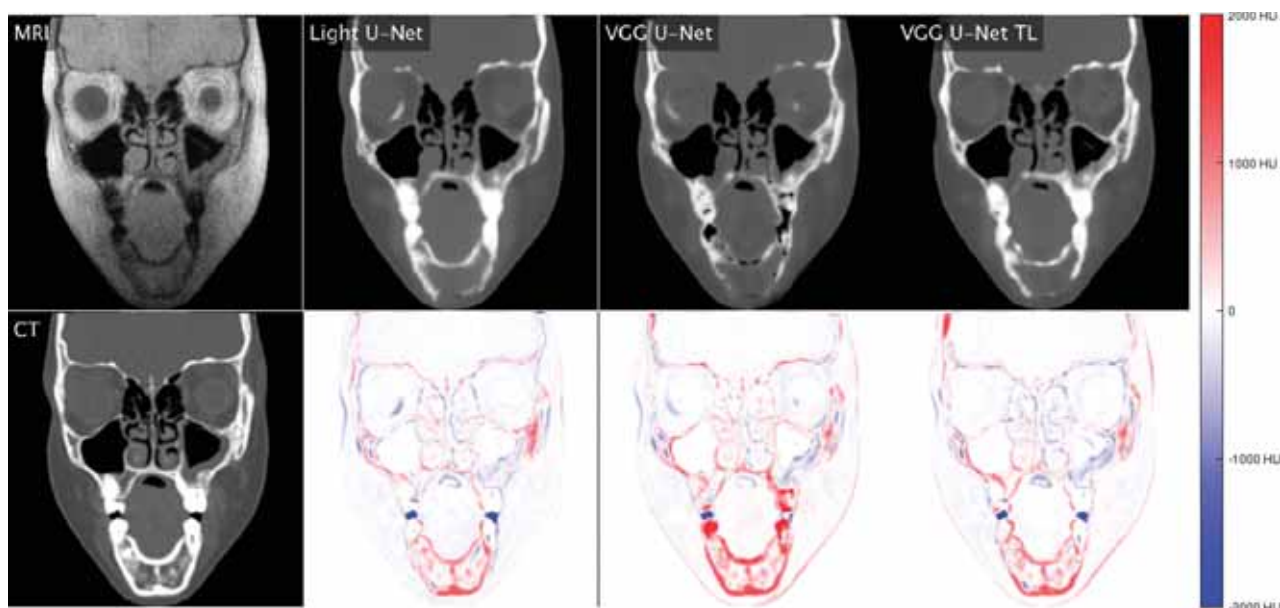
Comparison of different encoder-decoder models. The first column shows real MR imaging and real CT. Subsequent columns show synthetic CTs generated by Light_U-Net, VGG U-Net, and VGG U-Net transfer learning, as well as pixel-wise difference maps between synthetic CT and real CT. Red indicates that synthetic CT is darker than real CT; blue, synthetic CT is brighter than real CT (Refer online version for colors).
